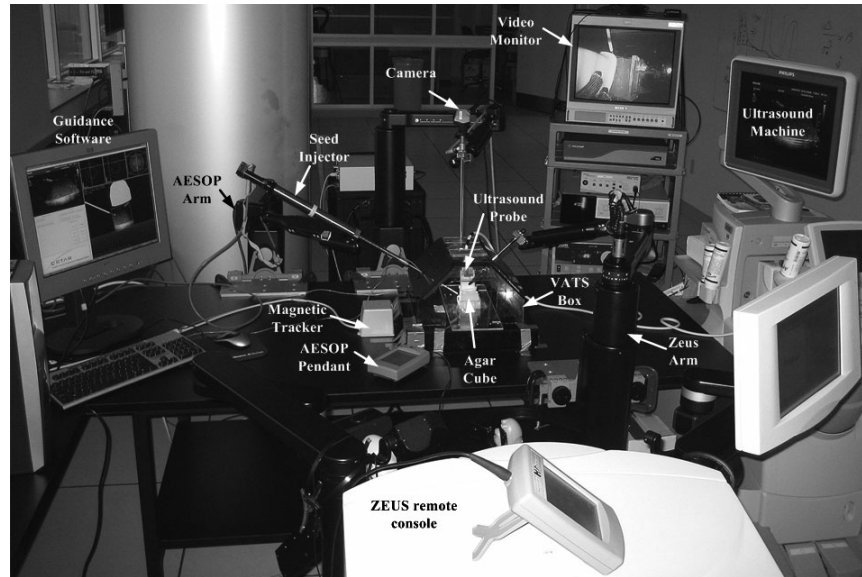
The experimental test-bed for lung brachytherapy consists of a VATS box, surgical robotic arms, a seed injector, an ultrasound machine, an electromagnetic tracking system, video monitors and an endoscope [99].
